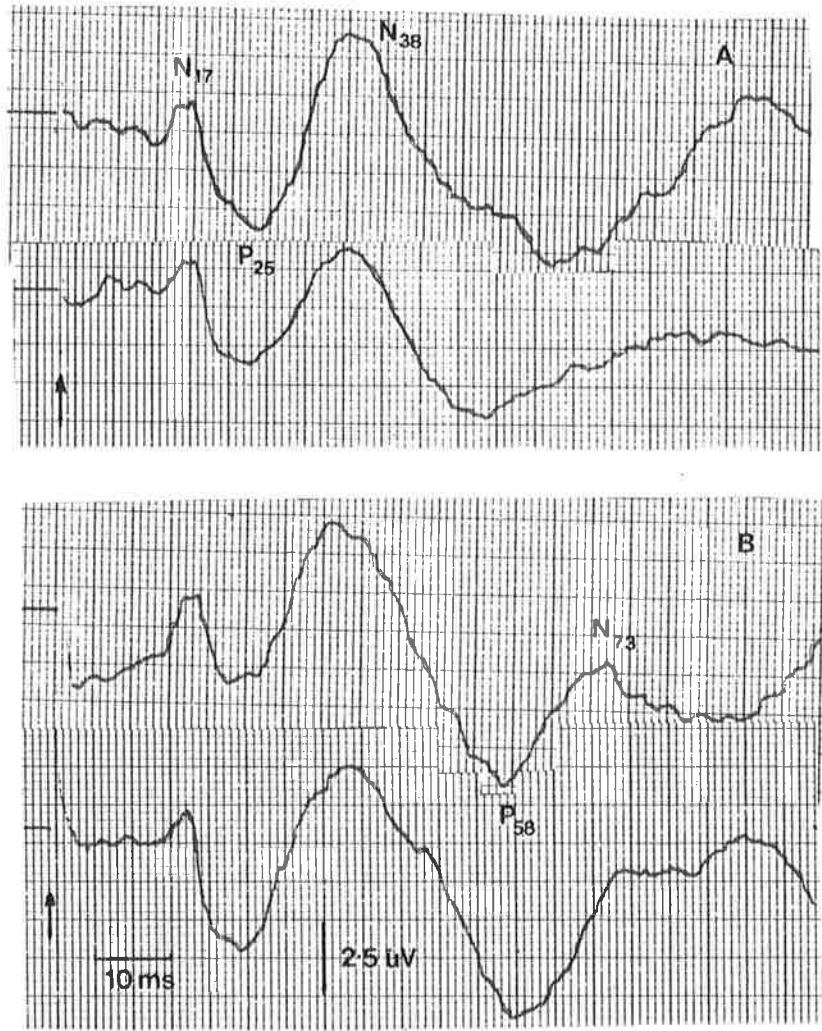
Cortical SEPs following median nerve stimulation from case 4. This seven year old boy presented with focal seizures. His CT scan showed a heavily calcified left posterior temporal lesion that had caused deformation of the skull (Fig 6.2b). Despite the presence of this oligodendroglioma the only difference between left (traces A) and right (Traces B) SEPs is ipsilateral loss of the N73 component.
